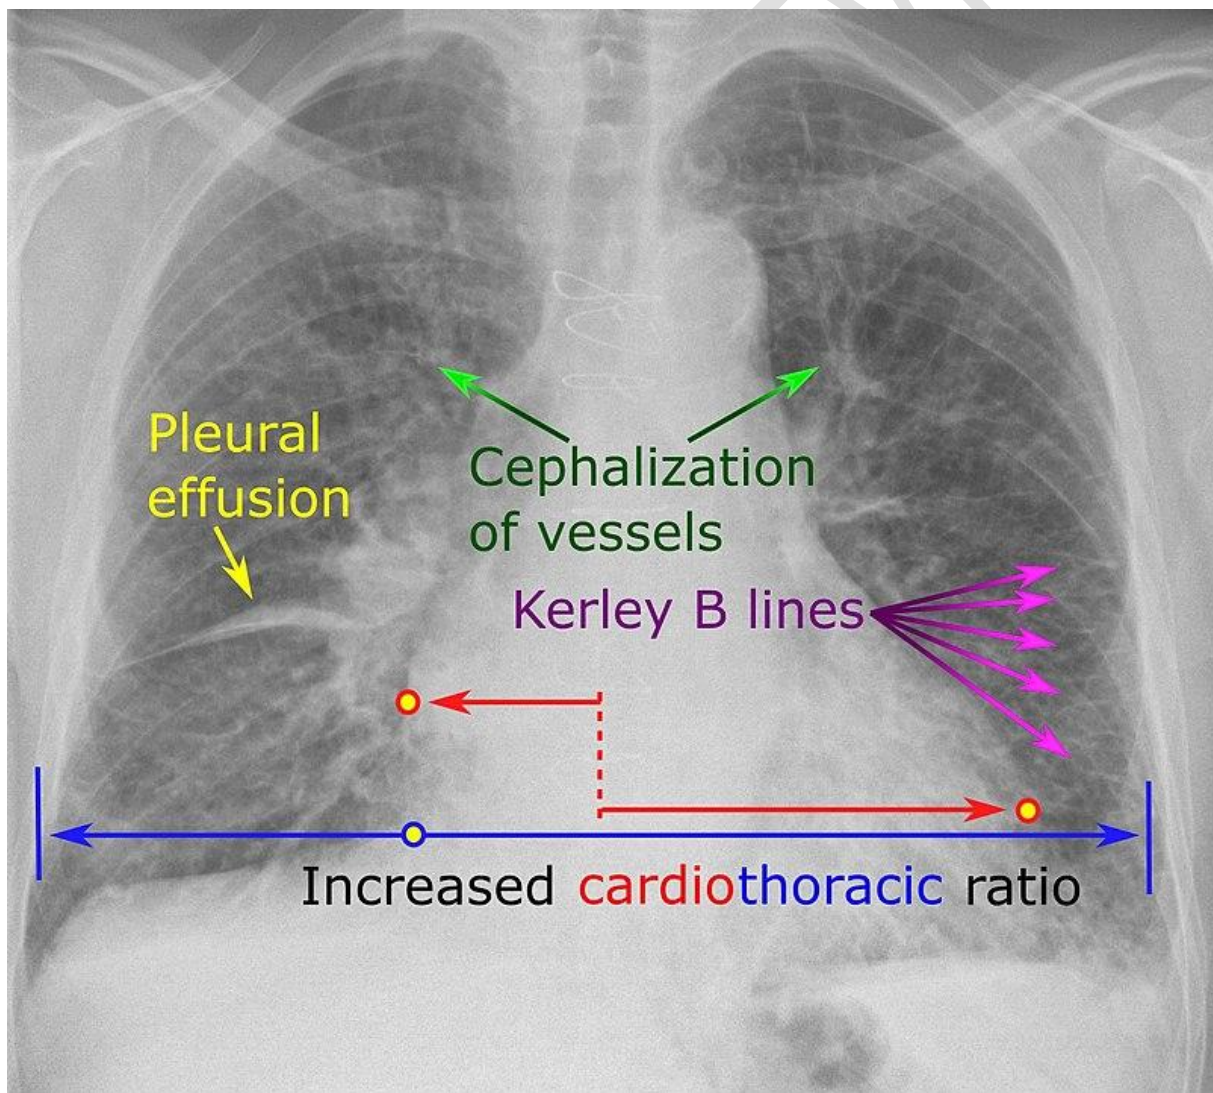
Chest X-ray of Congestive Heart Failure (14)
